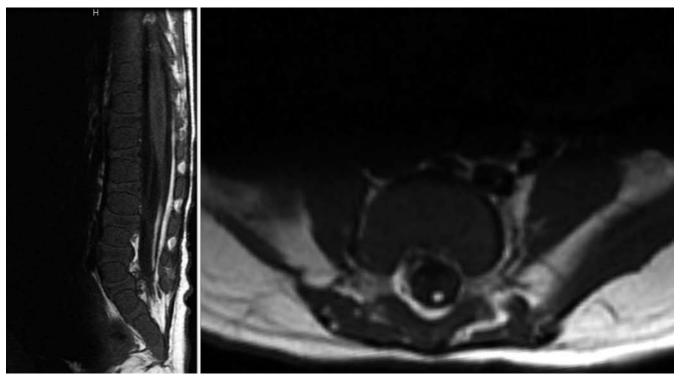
Sagittal (A) and axial (B) T1-weighted MR images of 5-month-old patient. The conus medullaris terminates at the mid L-3 vertebral body, with marked thickening and fatty infiltration of the filum. The sagittal image demonstrates a syrinx that extends into the lower thoracic cord.
